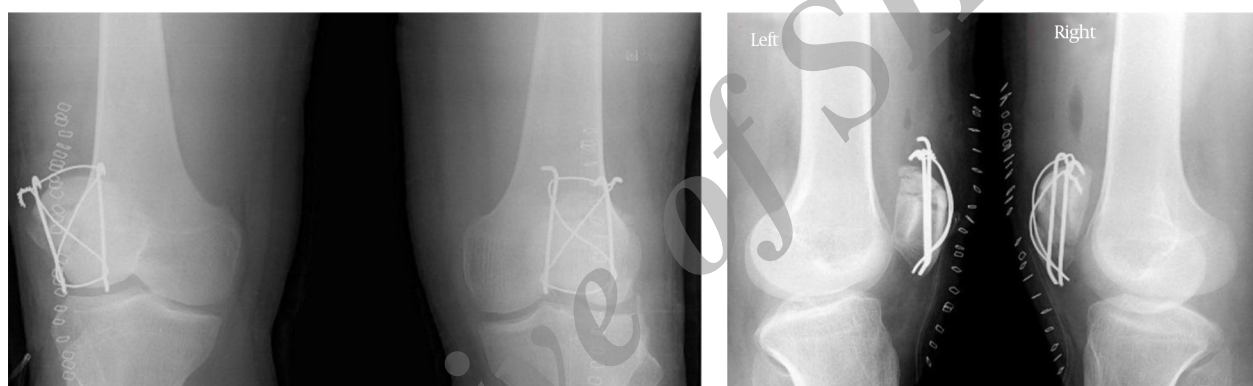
Post-Operative X-rays (Antero-Posterior and Lateral Views) Both Knees
